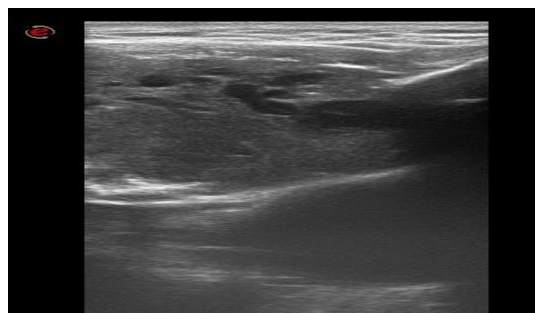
Ultrasound of sternum showing large hypoechoic heterogenous mass
